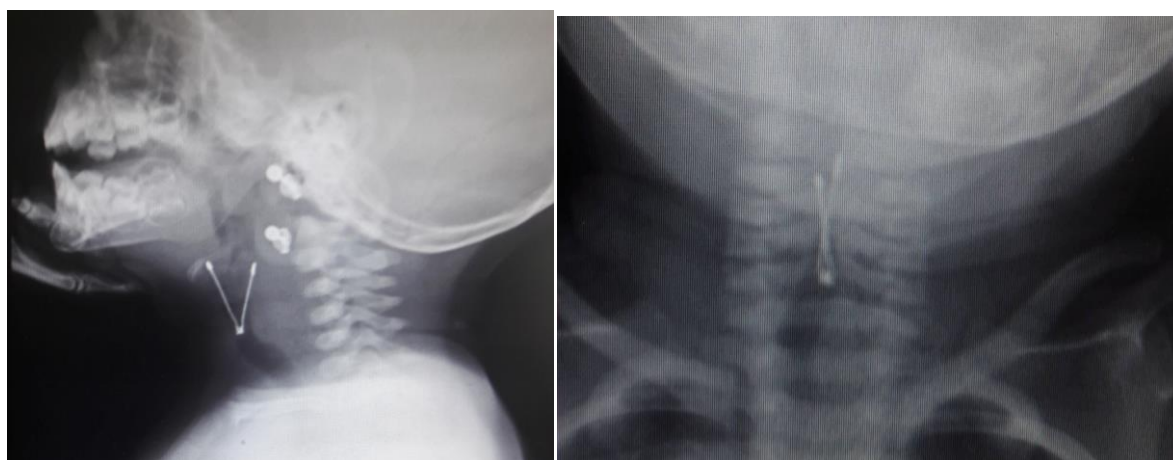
The X-ray image of the neck: a — sagittal plane; b — frontal plane. There is a shadow of a V-shaped foreign body of metallic density, pointed downward at the level of C2-C4 in the projection of the larynx
